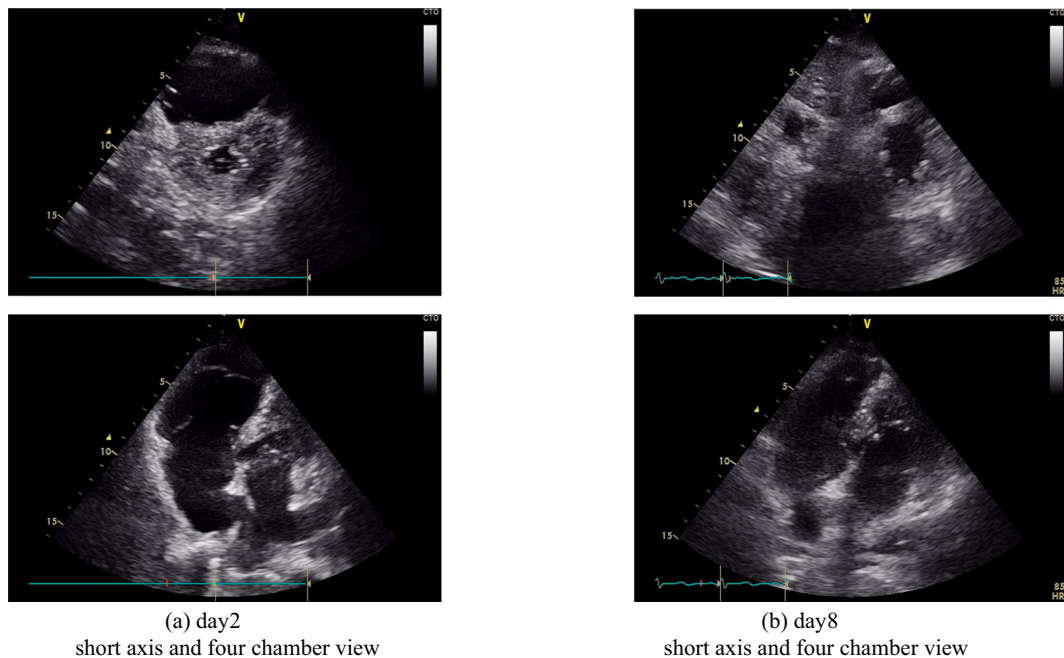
(1A performed on day 2, 1B performed on day 8) Echocardiography revealed enlargement of the right ventricle and atrium (short-axis and four-chamber view). After the patient did not require ECMO support.
